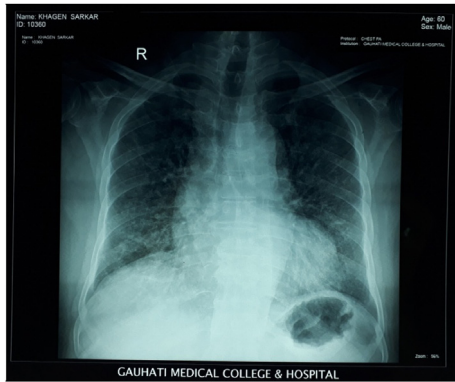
Chest xray after 9days of steroid administration (Day 12 of hospitalisation) showing complete resolution of opacities compared to previous film.
